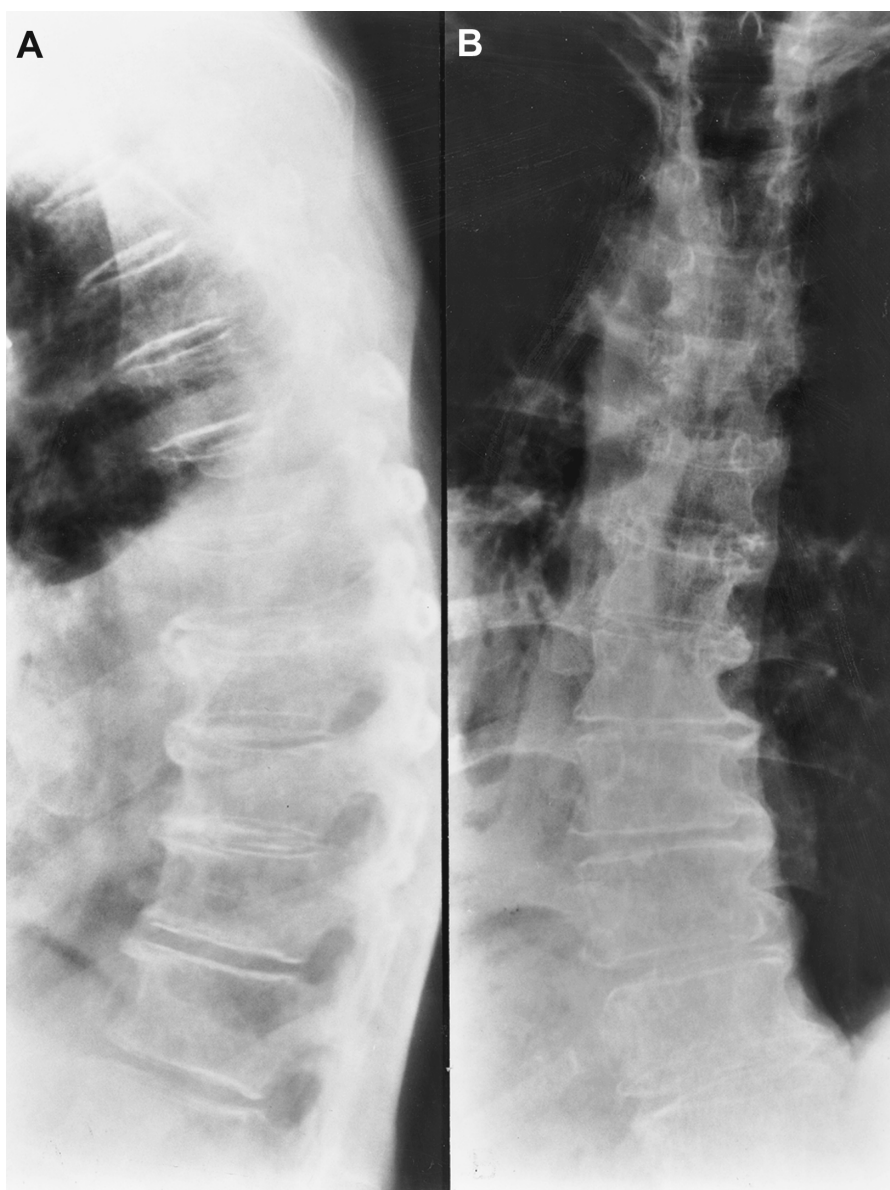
Patient with carcinoma of the breast with a history of back pain and osteolytic metastases. (A,B) Plain roentgenograms of the thoracic spine in the lateral and anterior posterior projections were normal. A bone scan was also normal. (C) Sagittal multiplanar-gradient echo T₂-weighted image reveals multiple hyperintense foci (arrows) indicating osteolytic metastases. (D,E) Sagittal T₁-weighted images of thoracic and lumbar spine reveal multiple hypointense foci (arrows) affecting almost all of the visualized vertebral bodies. (*continued*)
